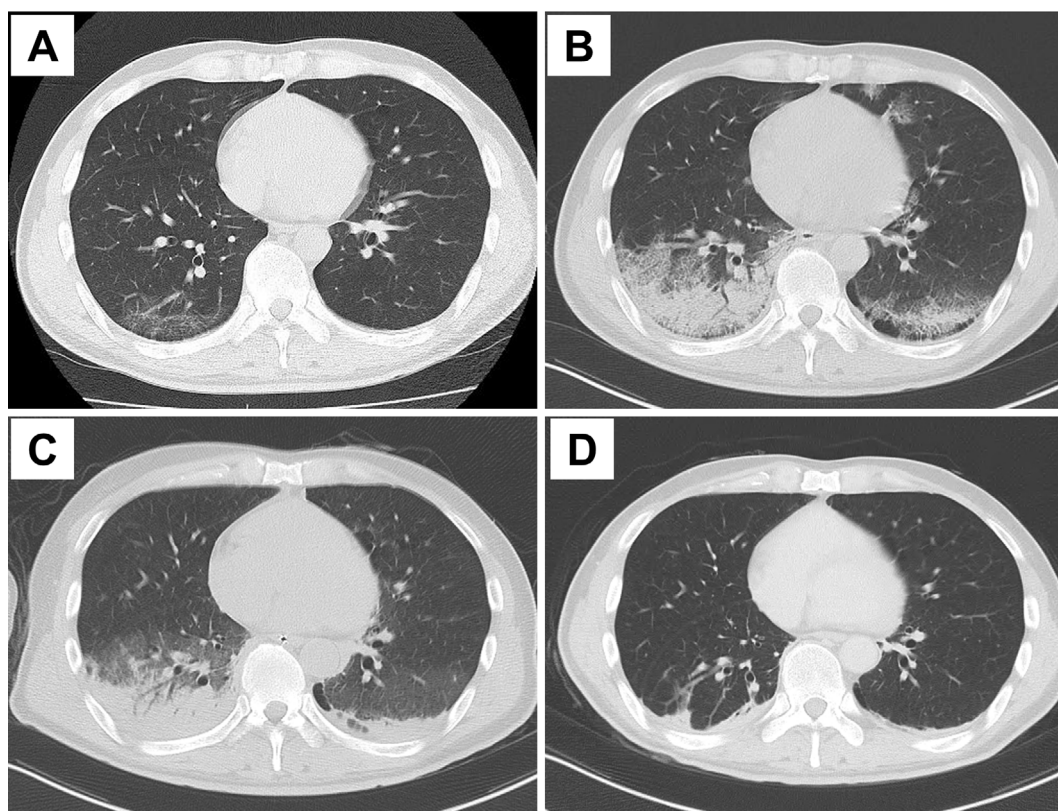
Thoracic computed tomography images after hospitalization. Ground-glass opacities were observed in the lower lobe of the right lung on day 4 (A), which changed into consolidation in the bilateral lungs on day 9 (B). On day 19, when the patient experienced respiratory and circulatory failure, the consolidation in the posterior basal regions increased in density (C). Consolidation in the bilateral lungs mostly disappeared on day 34 (D).
